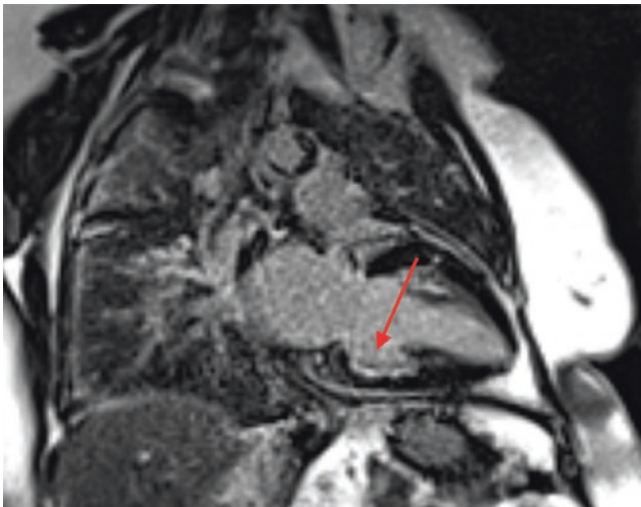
This is an MRI coronal view with delayed enhancement using gadolinium contrast. It shows a subendocardial basal inferior scar. Courtesy, Dr. Joel Fishman, University of Miami, Miller School of Medicine
